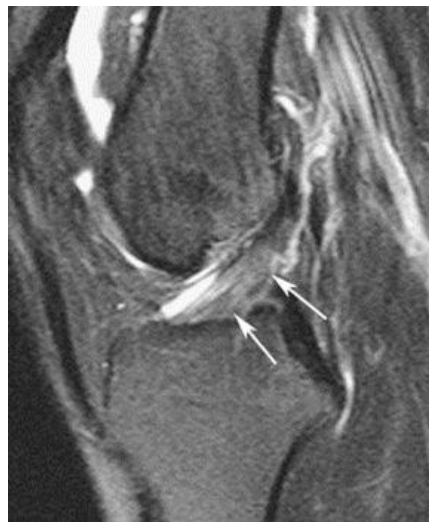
Sagittal MRI image shows a partial tear in the anterior cruciate ligament. High signal in the distal segment of the ligament with continuity of the fibers (white arrows).
